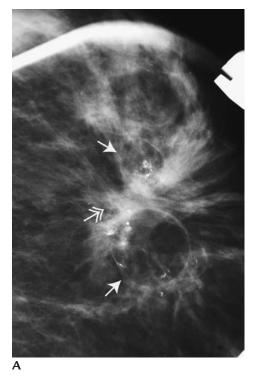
Fat necrosis. (A) Spot compression view. Mass (*double headed arrow*) with spiculated margins flanked by oil cysts (*arrows*) developing at a prior biopsy site. Coarse calcifications are present in the oil cysts. (B) Mass with associated shadowing (*double headed arrow*) corresponding to spiculated mass seen mammographically. Fat necrosis diagnosed on biopsy. Complex cystic masses (*arrows*), a common ultrasound appearance for oil cysts, flanking spiculated mass (*double headed arrow*).
